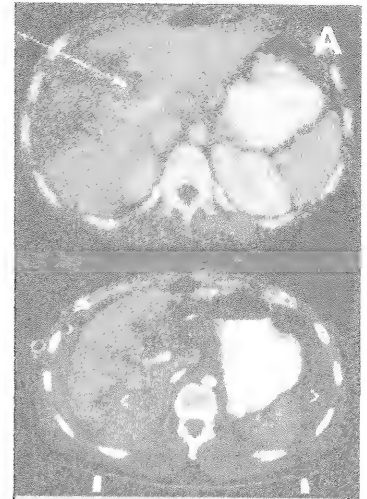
CT scans that show liver injuries.
